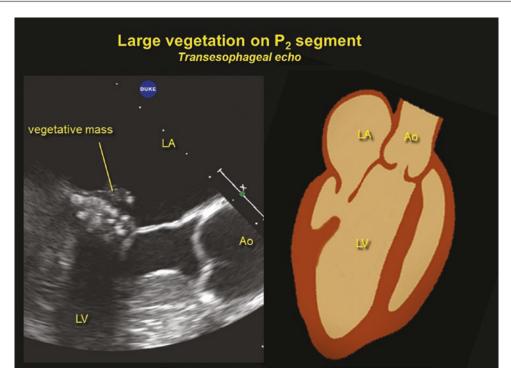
Transesophageal echo with a cluster of vegetations seen along the P_2 segment in a patient with endocarditis
